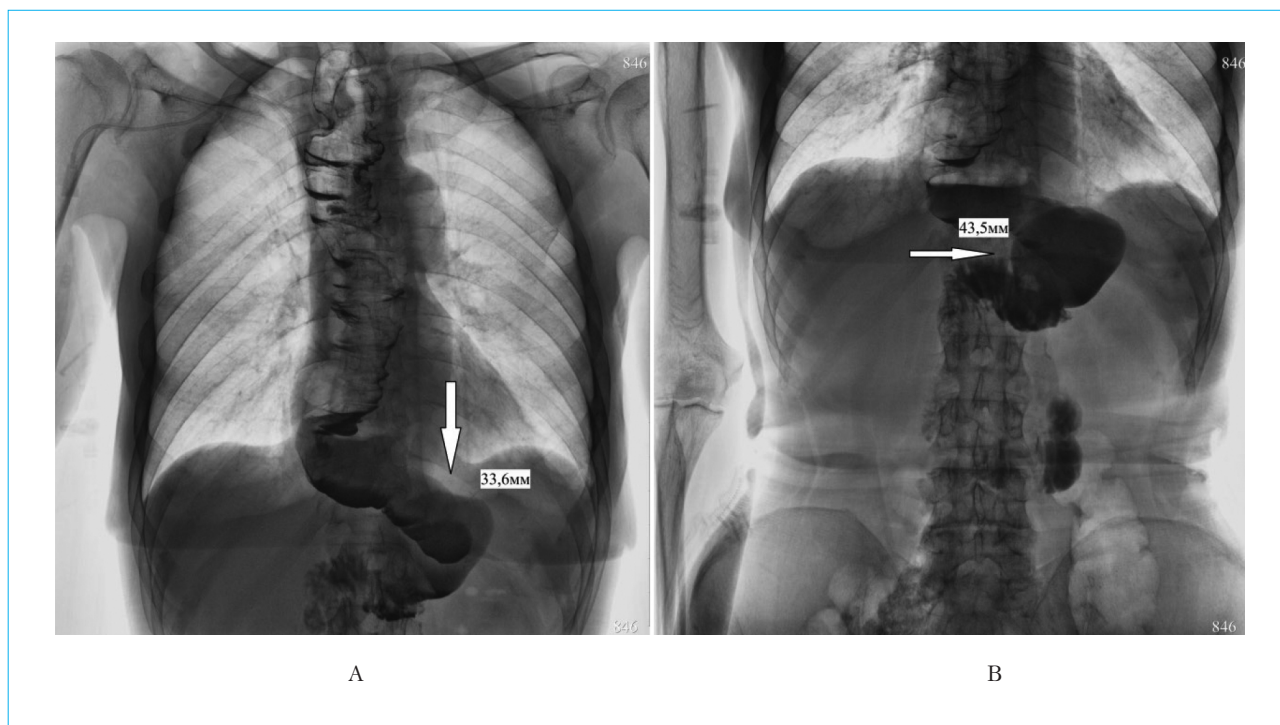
Radiographs of the coloenteric graft with oral administration of barium sulfate 1 year after surgery: arrows indicate the jejunal insertion immediately after administration of contrast (A) and in 3 minutes (B)
